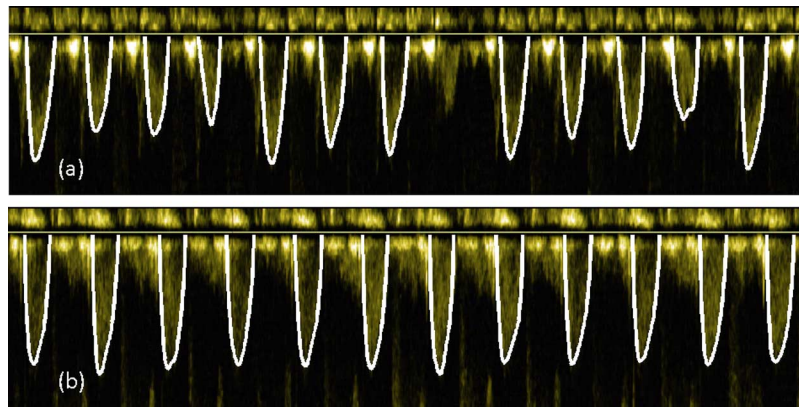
Two segments of Doppler strips with superimposed automated traces, for (a) patient 1 and (b) patient 3.
